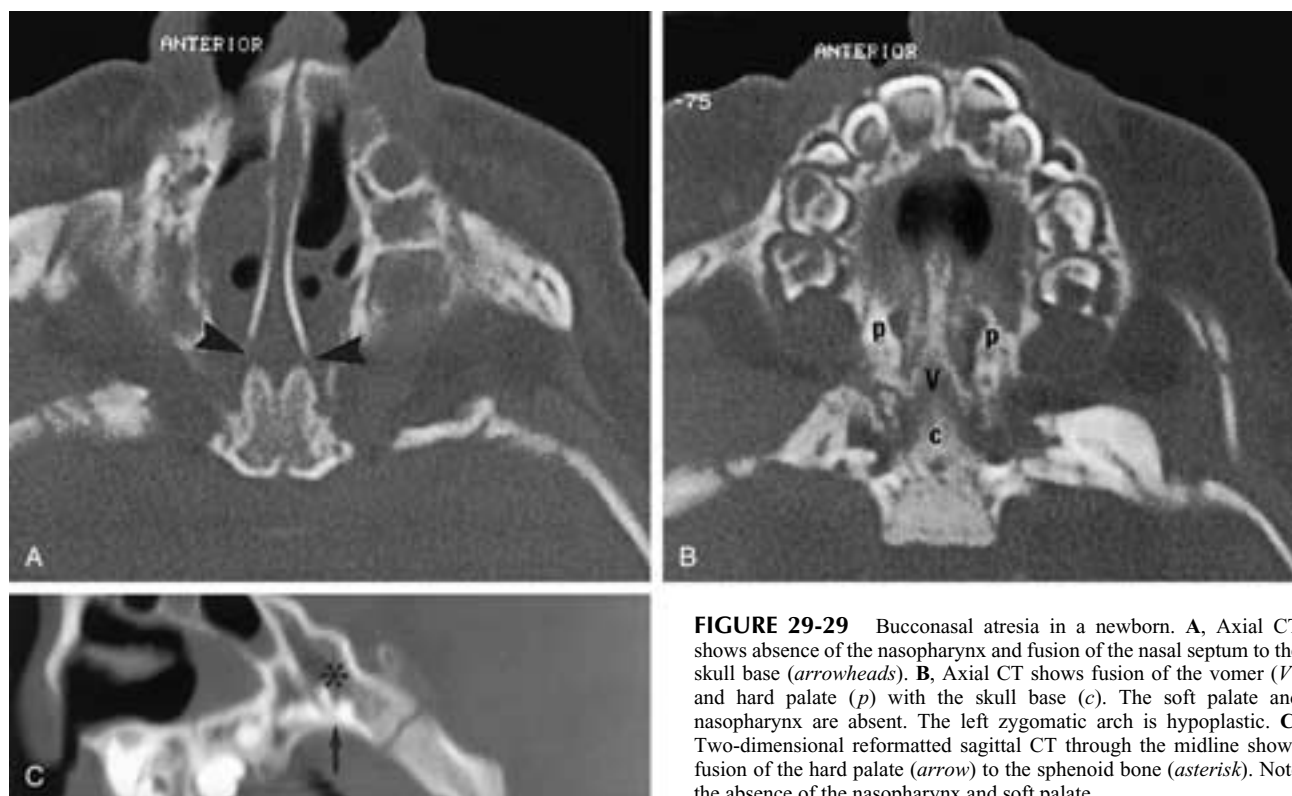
Bucconasal atresia in a newborn. A, Axial CT shows absence of the nasopharynx and fusion of the nasal septum to the skull base (arrowheads). B, Axial CT shows fusion of the vomer (*V*) and hard palate (*p*) with the skull base (*c*). The soft palate and nasopharynx are absent. The left zygomatic arch is hypoplastic. C, Two-dimensional reformatted sagittal CT through the midline shows fusion of the hard palate (arrow) to the sphenoid bone (asterisk). Note the absence of the nasopharynx and soft palate.
